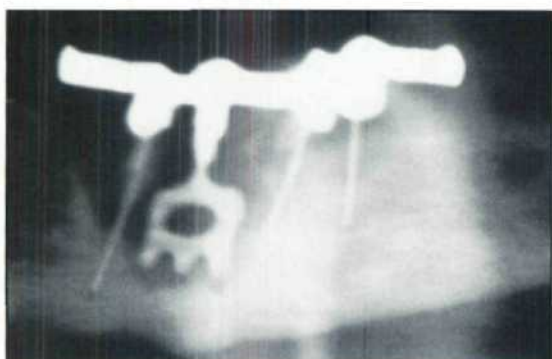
Panoramic radiograph of the patient at presentation.
